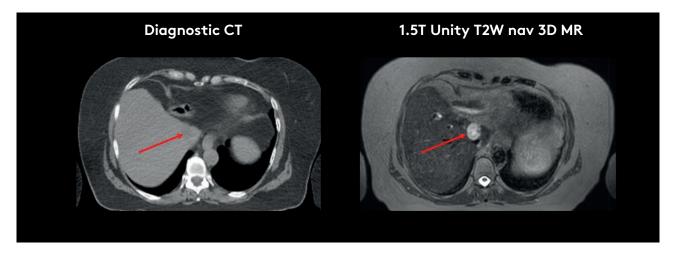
Comparison of diagnostic CT and 3D T2-weighted navigated MRI of a liver tumor. Clear visualization of the target and OARs enables fiducial-free liver SBRT. Images courtesy of Genesis Care St. Vincent's Clinic, Sydney
